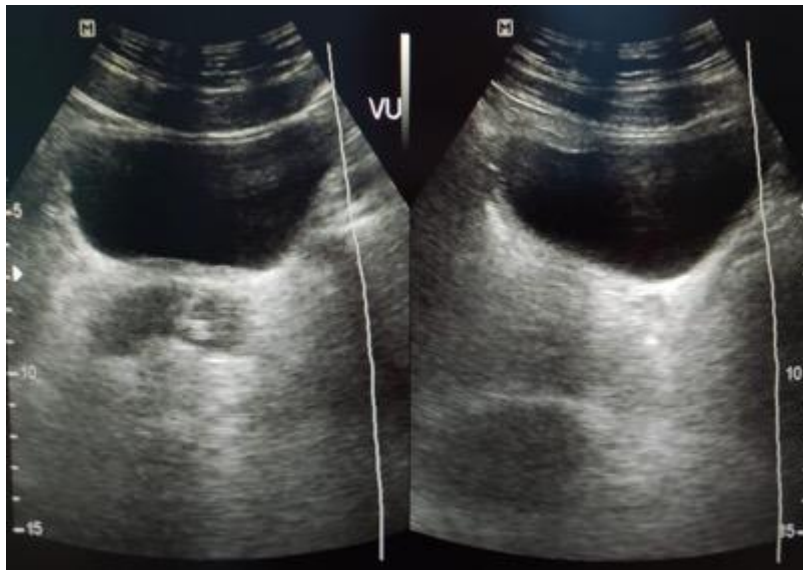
Normal bladder ultrasonography.
